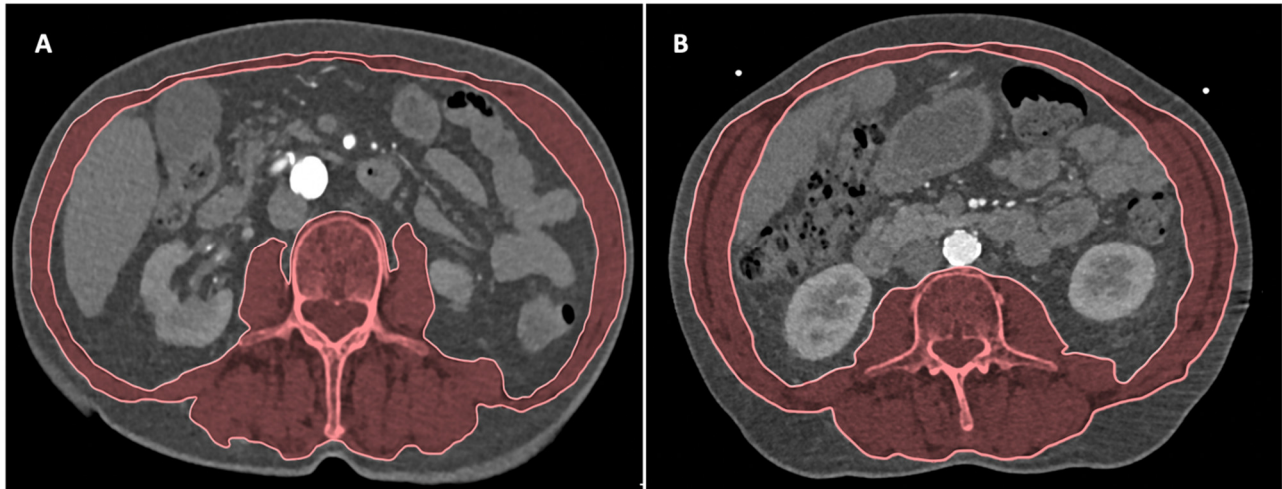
CT scans of a sarcopenic and a non-sarcopenic patient. (A) Sarcopenic patient. (B) Non-sarcopenic patient. Sarcopenic status was defined according to skeletal muscle index values $<55.4 \text{ cm}^2/\text{m}^2$ in males and $<38.9 \text{ cm}^2/\text{m}^2$ in females.
